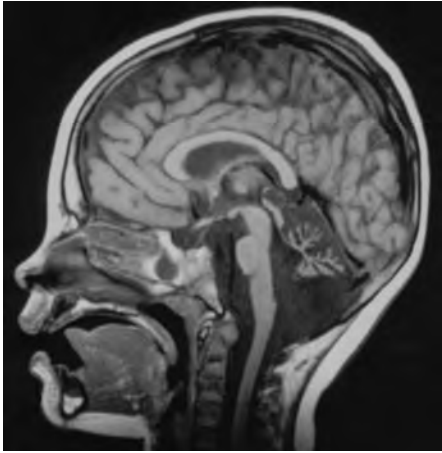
MRI showing cerebellar hypoplasia in a patient with PMM2-CDG.
